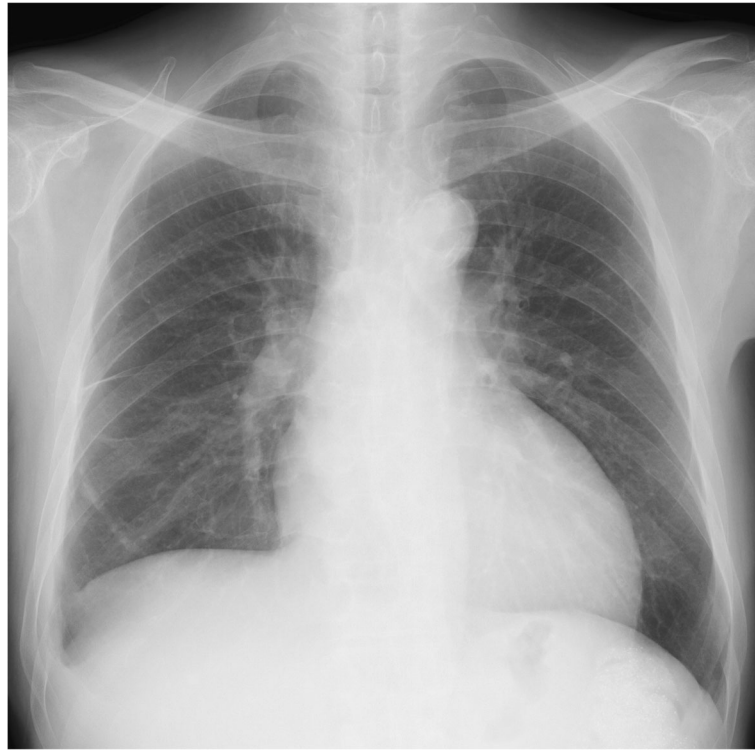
Chest X-ray performed 6 months after pleurodesis with autologous blood depicting apparent resolution of the hydrothorax
